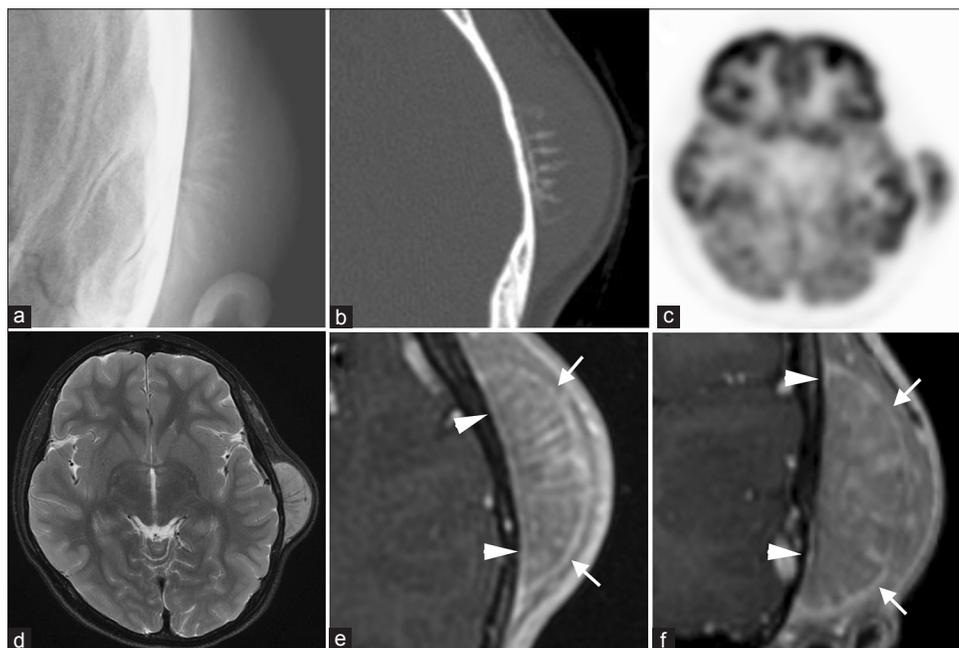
Preoperative images. A skull X-ray with dynamic range compression (a), axial computed tomography of the skull (b), F-18 fluorodeoxyglucose positron emission tomography (c), axial T2-weighted imaging (d), and postcontrast T1-weighted imaging of the axial plane (e) and coronal plane (f). Arrows and arrowheads indicate the enhanced outer and inner membranous structures, respectively
